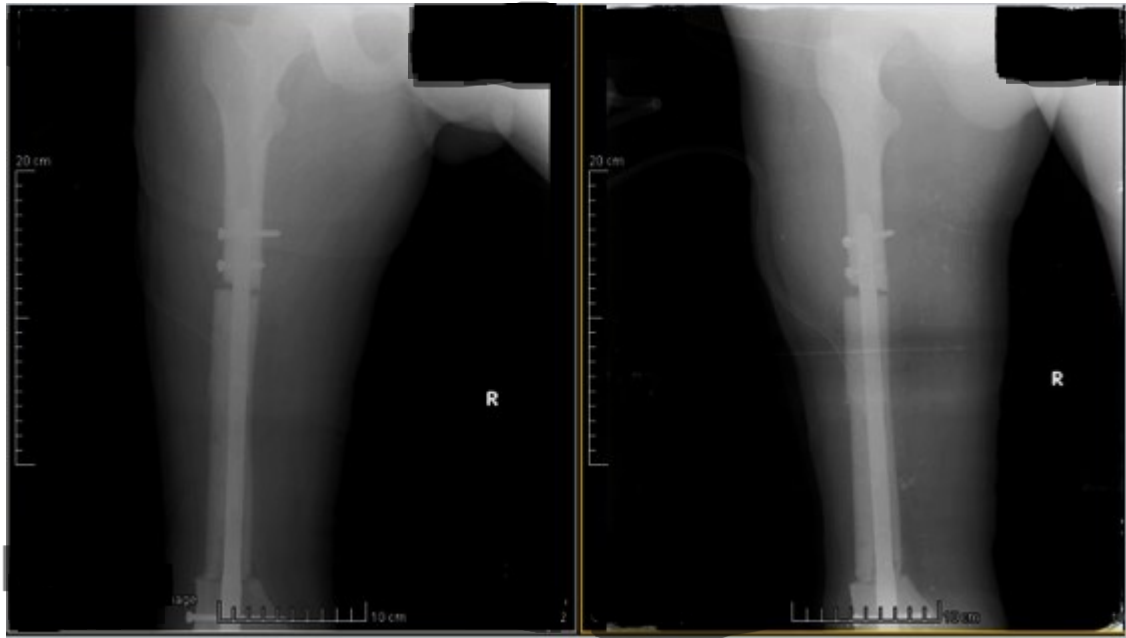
Postoperative X-ray after the First Surgery
